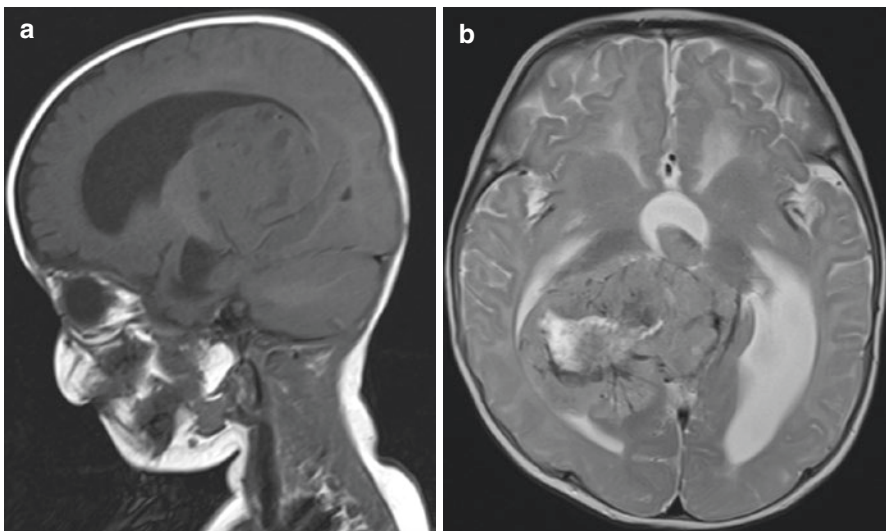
Teratoma in T1WI (a), and T2WI (b) MRI sequences
